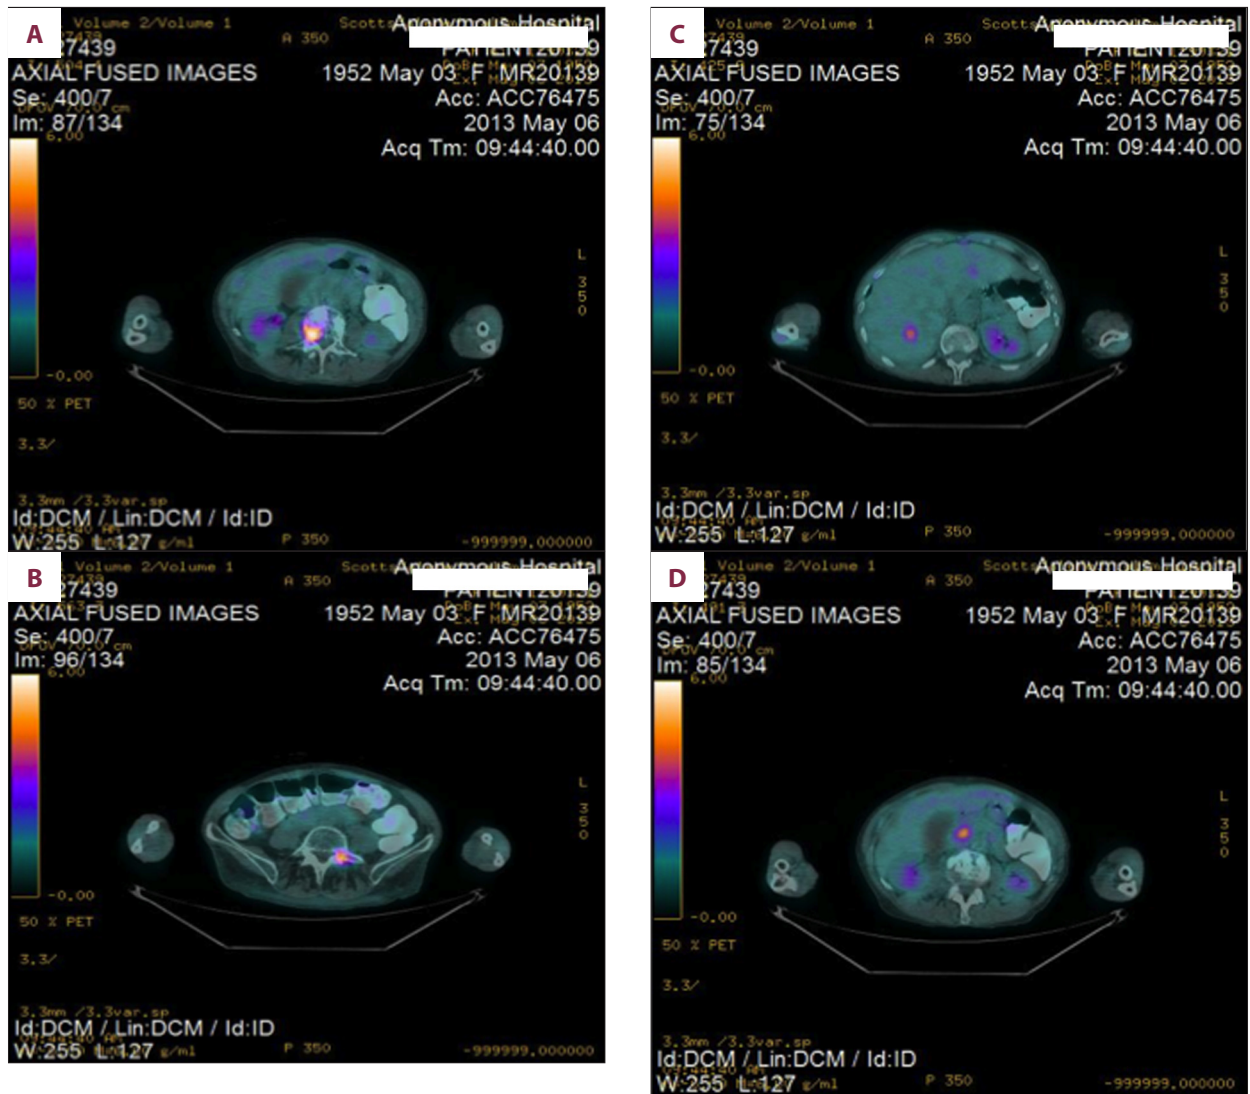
Radiographic study by PET scan. (A) Metabolically active lesion at right L3 pedicle and posterior vertebral body. (B) Metabolically active lesion at left L5 pedicle. (C) Metabolically active lesion within the liver. (D) Metabolically active lesion within the pancreatic head.
